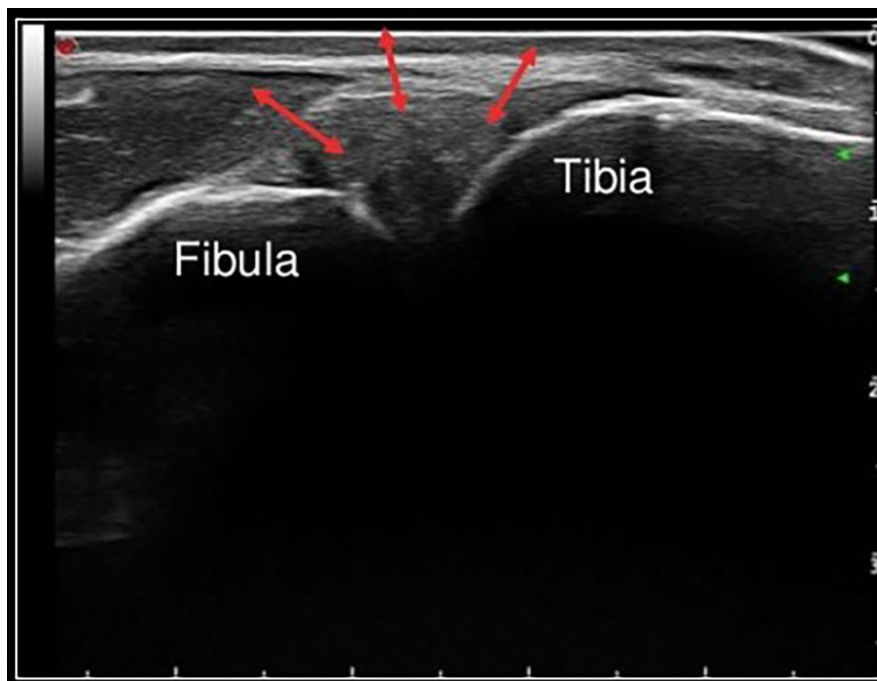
Ultrasound examination of the anterior syndesmosis. The bone contours of the tibia and fibula can be clearly identified. In experienced hands, the soft tissue quality of the AiTFL can be determined. Furthermore, US is the only imaging, which allows a dynamic examination.
